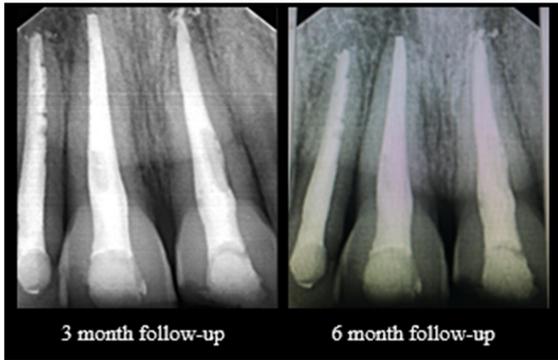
Radiographic Images of 3 months and 6 months follow up
